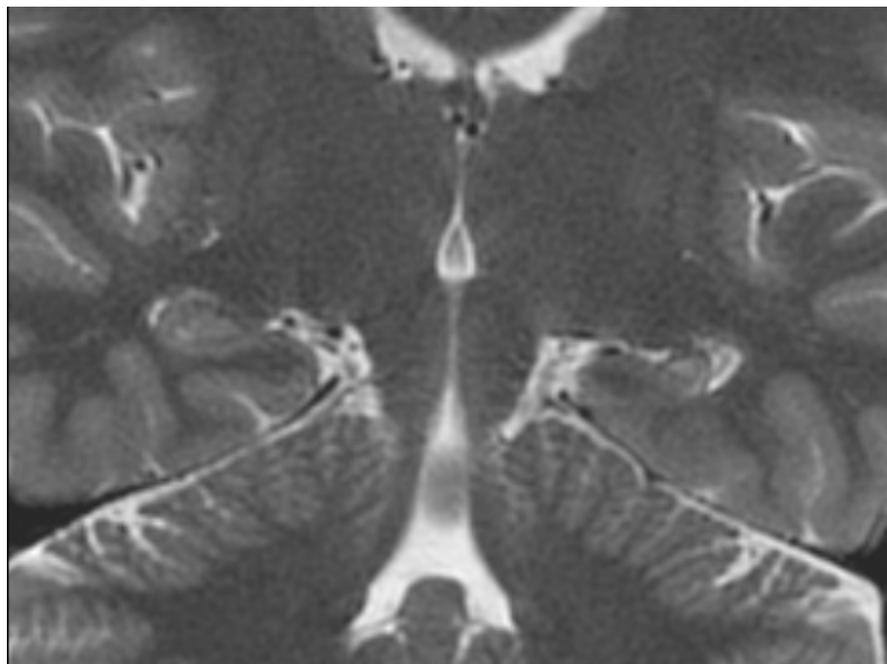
A coronal T2-weighted magnetic resonance imaging scan showing atrophy and increased signal in the left hippocampus (hippocampal sclerosis). Note that the left of the patient is on the right side of the image.
